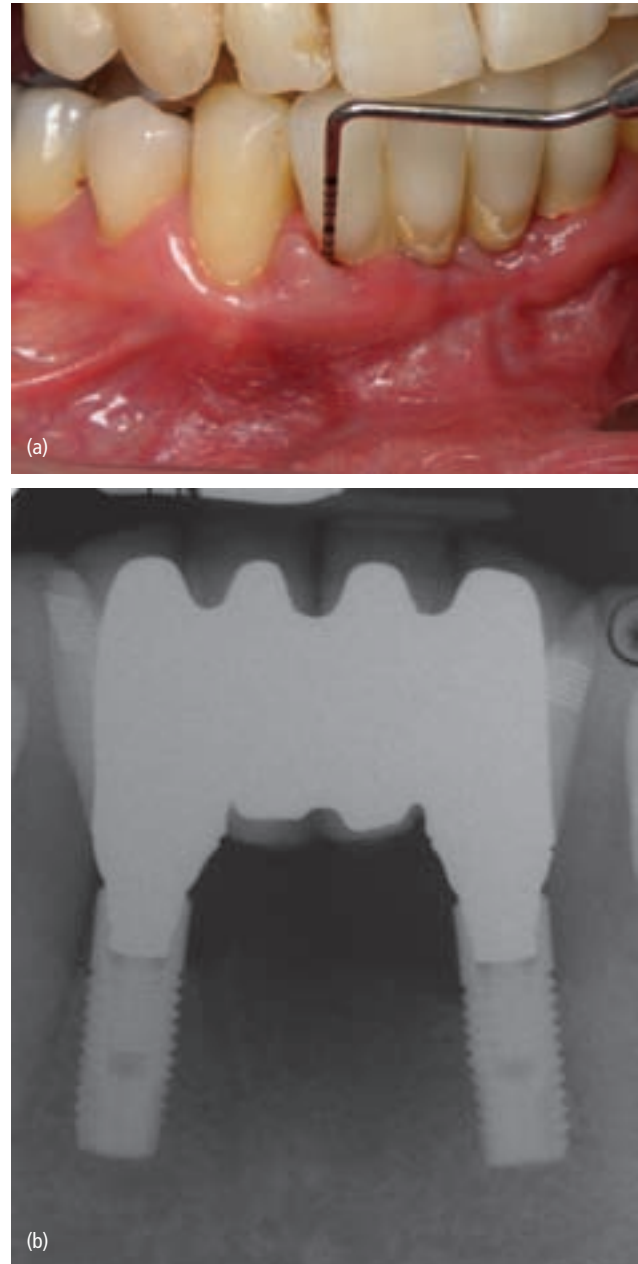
(a) Peri-implantitis presenting with changes in color, form, texture, and associated bone loss resulting in increased probeable depths. (b) Peri-implantitis radiographically demonstrates crestal bone resorption.
